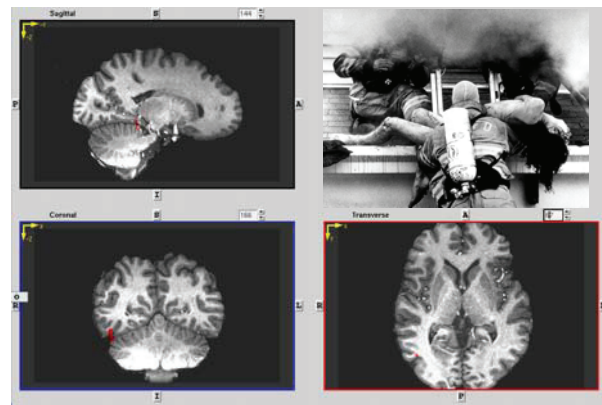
Baseline functional MRI of patient patient CC, who developed interferon-induced depression after two weeks of treatment. A representative section of the baseline brain MRI of one (CC) of the initial test subjects who did develop CNS symptoms (clinically significant depression) after only two weeks of interferon therapy. Visual stimulus #4 (Figure 4) was used to generate this scan. The lack of significant activation is consistent with that of individuals who did not experience depression at baseline (Figure 5) or after interferon treatment (Figure 6).
